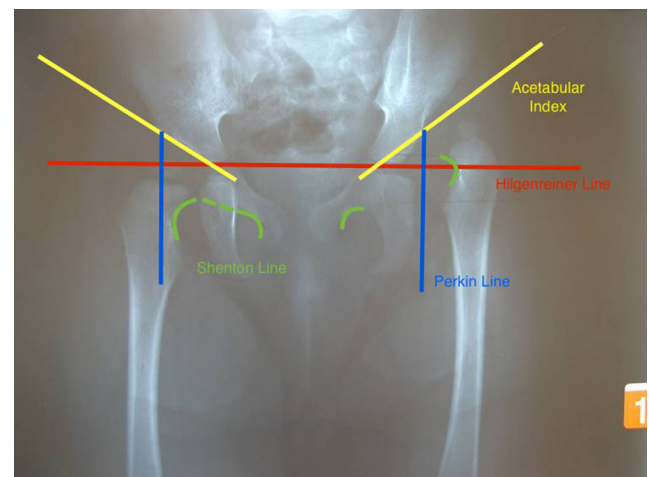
Radiograph showing a left dislocated hip and severe dysplasia of the acetabulum. Shenton’s line is broken and has an increased acetabular index on the left
